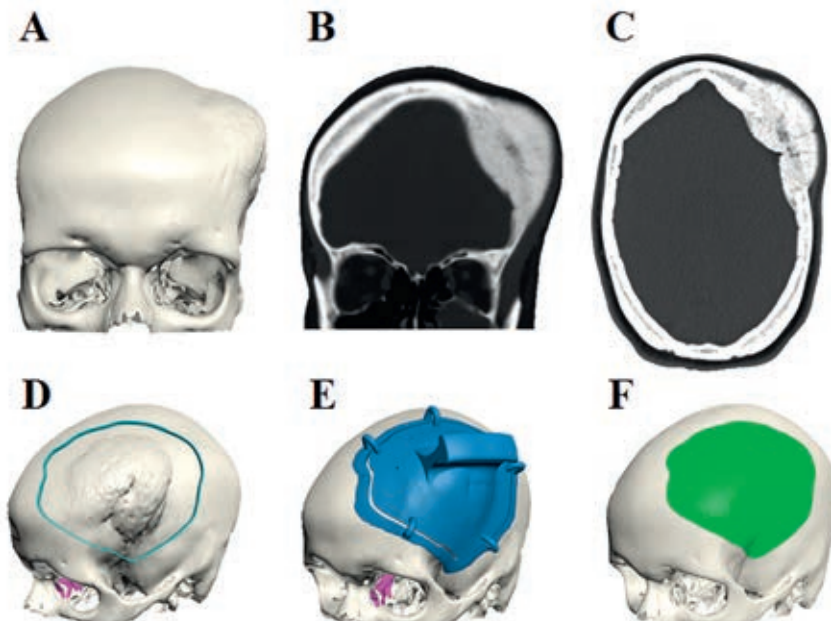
A) 3D rendering of CT data, B) CT coronal coupe, C) CT axial slice. Preoperative planned, D) resection outline of the meningioma, E) nylon resection template, F) patient specific implant designed by using a mirroring technique
